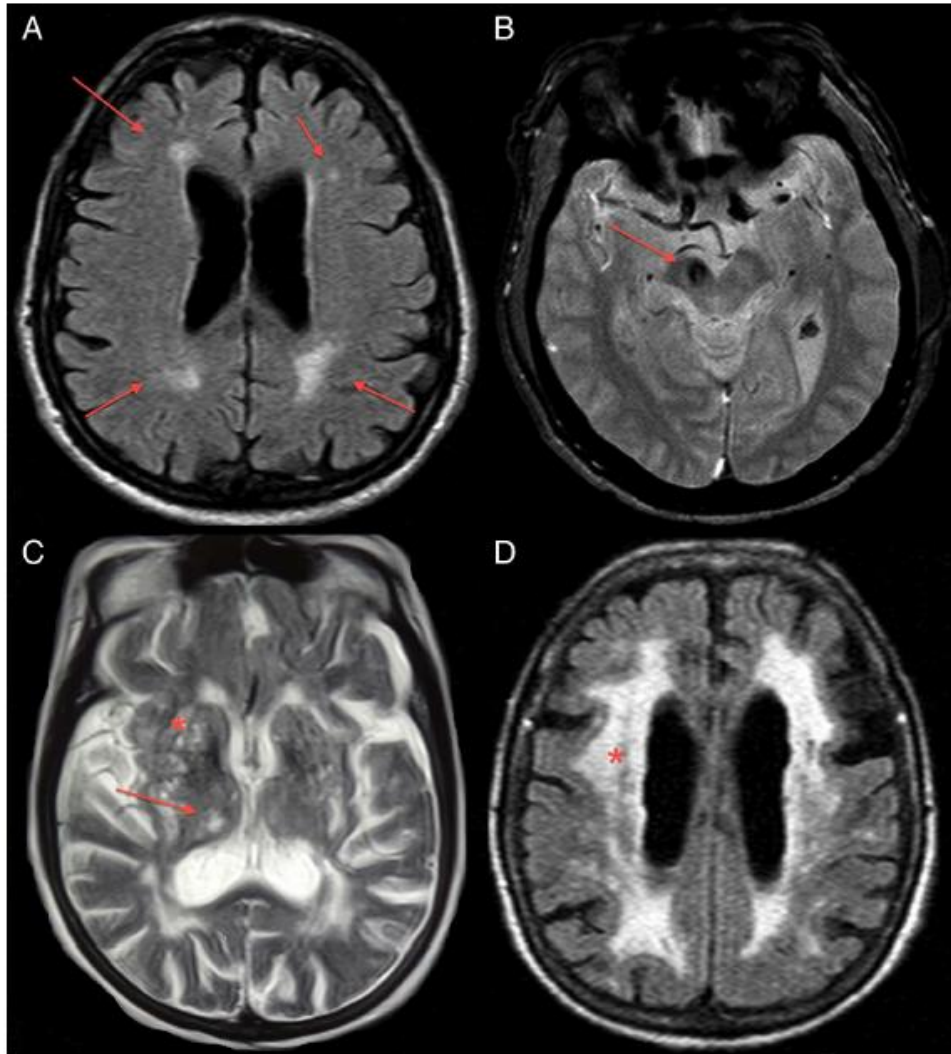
(A) T1-weighted-sequenced brain MRI showing mild cortical atrophy and non-specific periventricular white matter changes (red arrows) in a 65-year-old patient with hypertension and Parkinson's disease; (B) Spin-echo-sequenced brain MRI showing a single right midbrain lacunar infarct (red arrow) in a 62-year-old patient with vascular parkinsonism; (C) A T2-weighted-sequenced brain MRI showing multilacunar infarcts in the basal ganglia (red asterisk), thalami (red arrow) and internal capsules in a 76-year-old patient with vascular parkinsonism; (D) fluid-attenuated inversion recovery-sequenced brain MRI showing extensive white matter lesion (red asterisk) in a 72-year-old patient with vascular parkinsonism.
